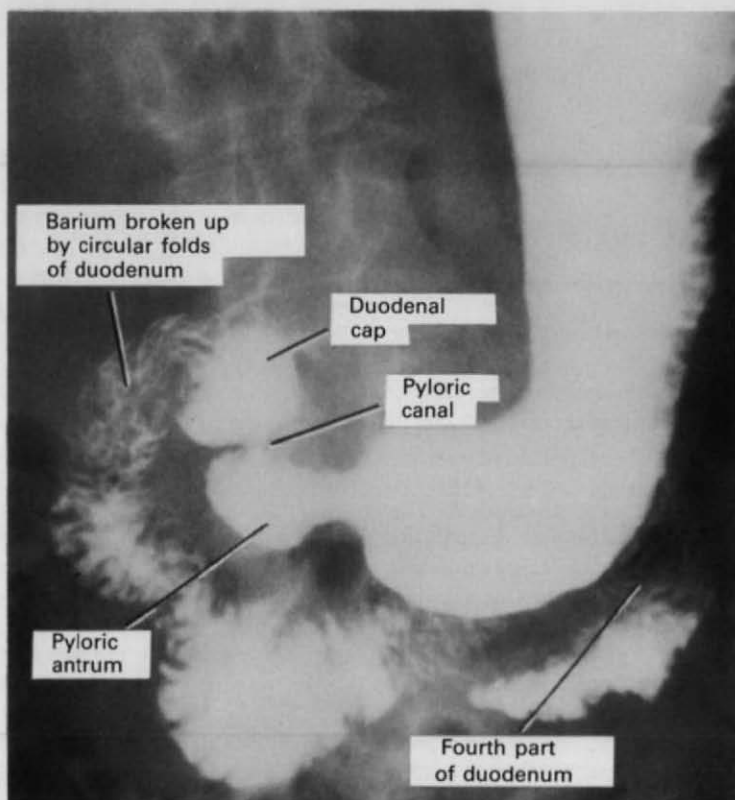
Radiograph of the stomach and duodenum after a barium meal.
